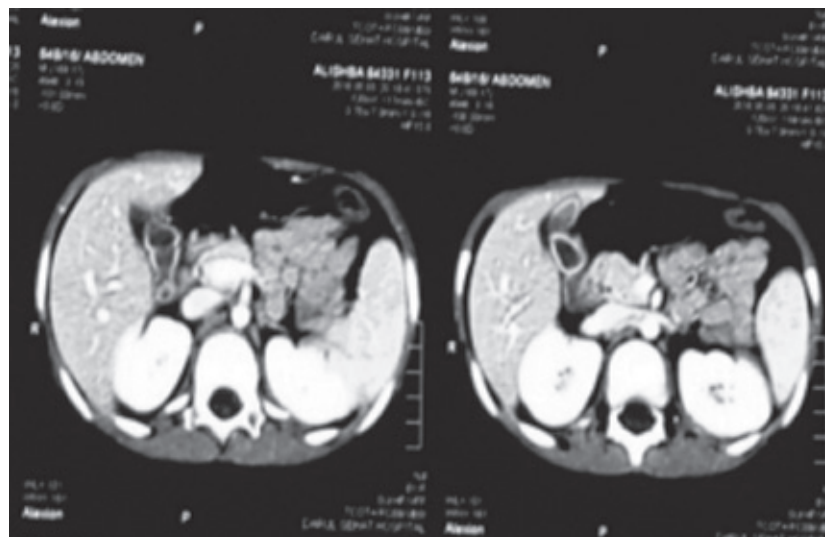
CT abdomen with contrast showing diffuse gall bladder wall thickening and enhancement with free fluid and surrounding lymph nodes
